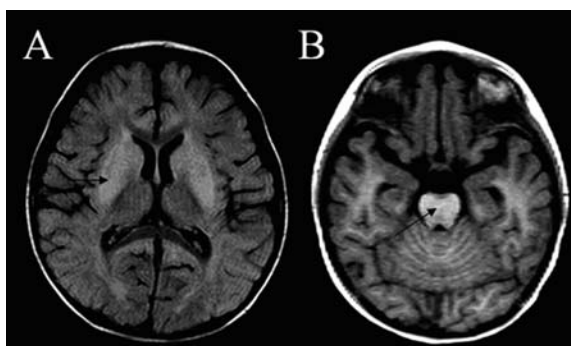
On hospital day 8, an axial T2-weighted magnetic resonance image demonstrates areas of increased T2 signal intensity within the basal ganglia (A, arrow) and central pons (B, arrow).
